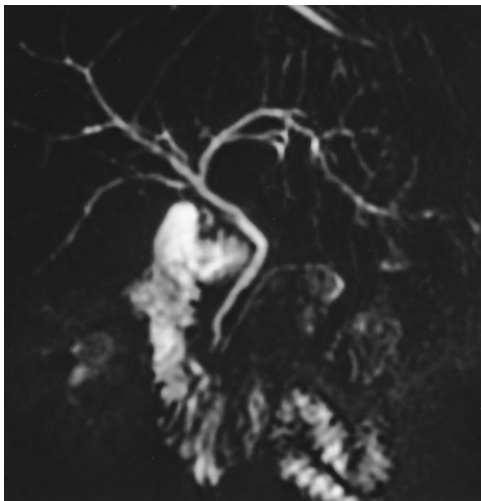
Eosinophilic cholangitis in a 42-year-old woman with jaundice and eosinophilia. Coronal MR cholangiopancreatography image shows subtle intrahepatic ductal irregularity. Note the peripheral ducts intersecting at right angles, which suggest an inflammatory process. (Copyright Vitellas et al. *Radiographics* 2000;20:959-975.)
